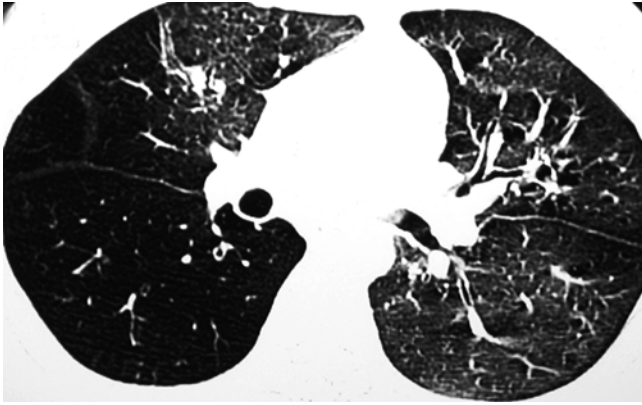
Swyer-James syndrome in a 10-year-old girl. HRCT shows reduced attenuation and paucity of bronchovascular markings in the right lung (Case courtesy of Winnie CW Chu, MD, from Hong Kong)
